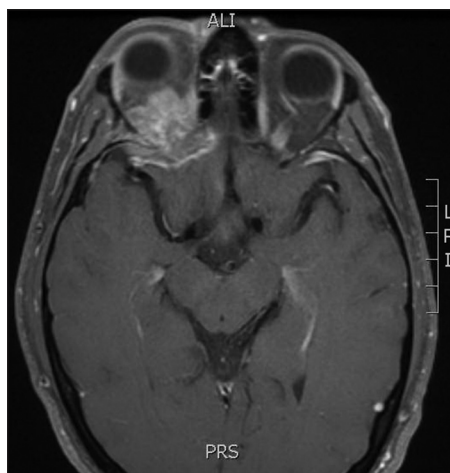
Brain magnetic resonance imaging demonstrating a 3.9 cm retro-orbital mass displacing the right eye anteriorly and also intracranial invasion
